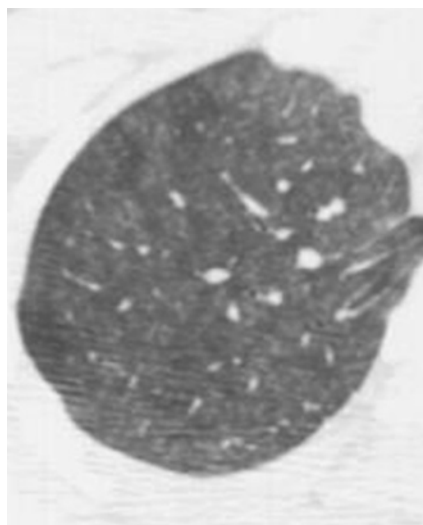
Hypersensitivity pneumonitis from residential exposure to mold. Axial high-resolution CT images of the right lung demonstrate centrilobular ground-glass opacities in a uniform distribution. (Case courtesy of Matthew Gilman, MD, Madigan Army Medical Center, Fort Lewis, Wash.)
